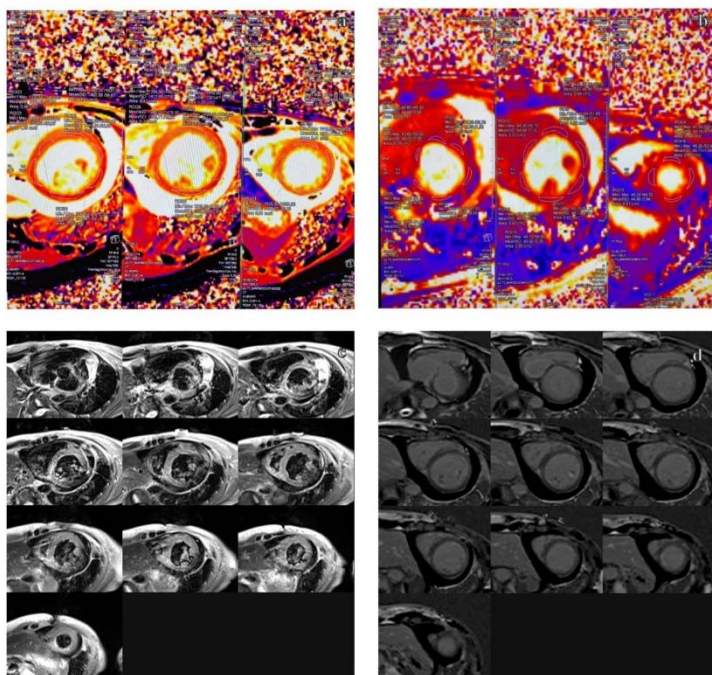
Cardiac MRI findings: (a) T1 mapping, (b) T2 mapping, (c) T2 STIR, (d) LGE.
